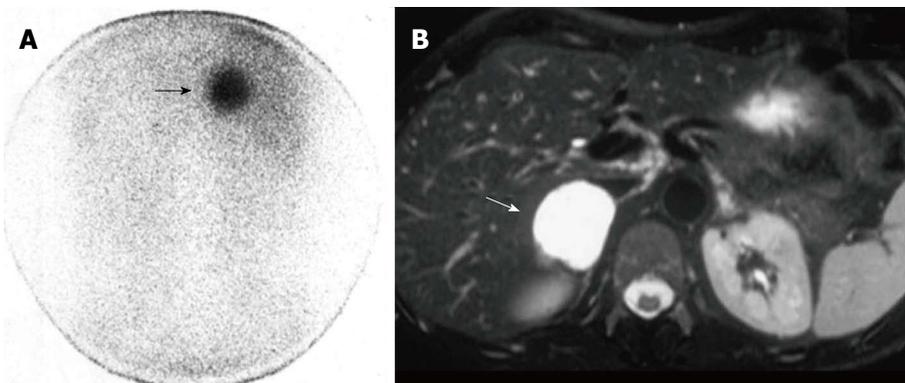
Right malignant hypersecreting pheochromocytoma. A: Abdominal posterior scan of I-131 metaiodobenzylguanidine scintigraphy demonstrates abnormal (intense) focal uptake in the right adrenal (black arrow) where a large mass was detected by magnetic resonance (MR); no detectable tracer uptake in the left adrenal bed; B: T2-weighted axial MR with fat-suppression detects a large right adrenal lesion hyperintense compared to liver signal intensity (white arrow).
